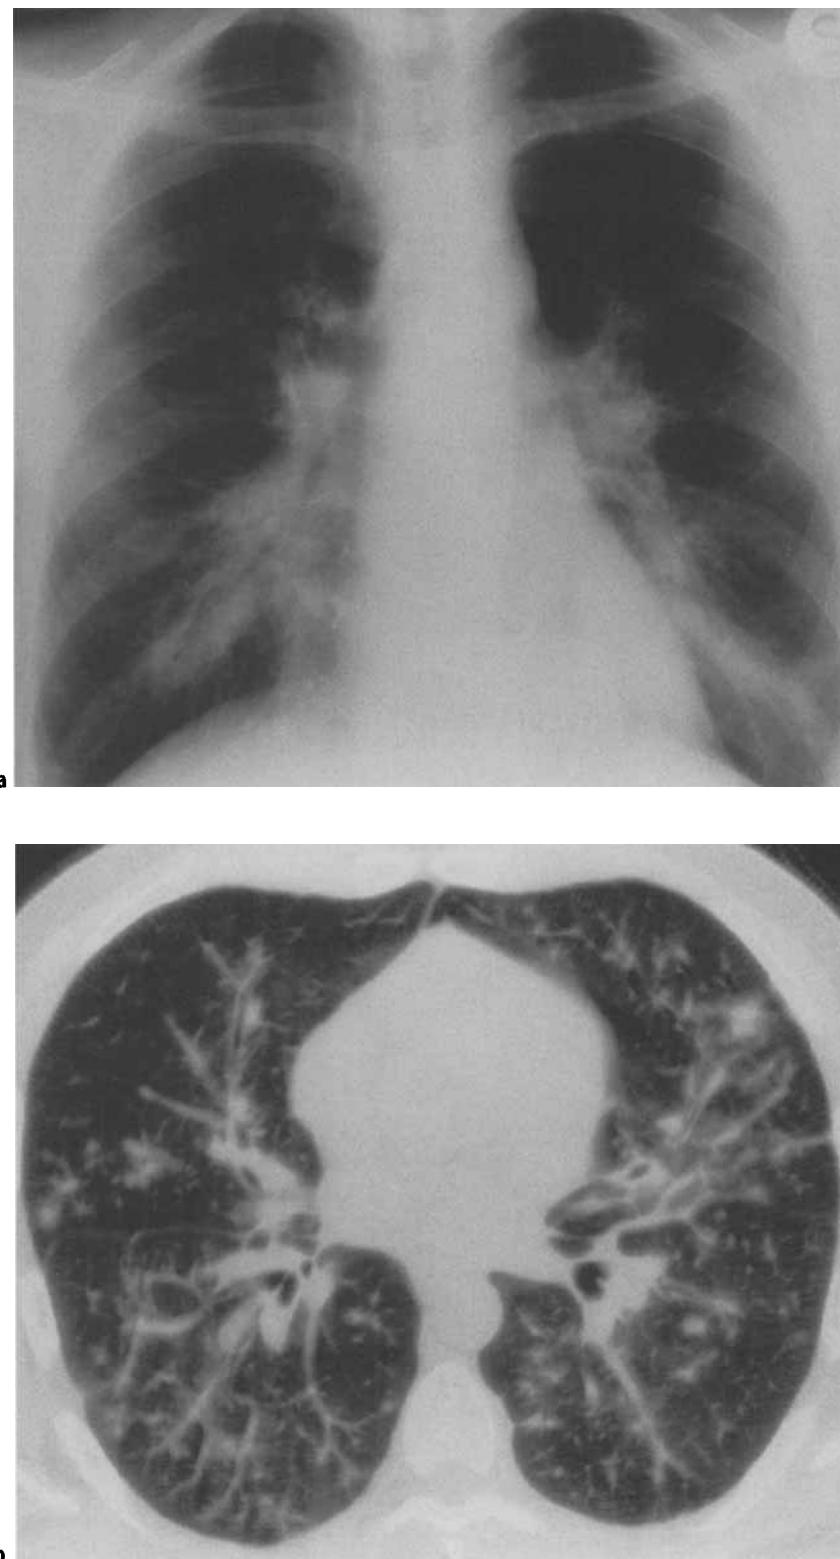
a, b. HIV-positive, drug addict, homosexual patient, with Kaposi's sarcoma, showing a bilateral interstitial pattern with thickening of bronchovascular bundles in the chest plain film (a). HRCT depicts very well the presence of ill-defined peripheral consolidations and nodular lesions, coupled with a diffuse interstitial involvement (b).
